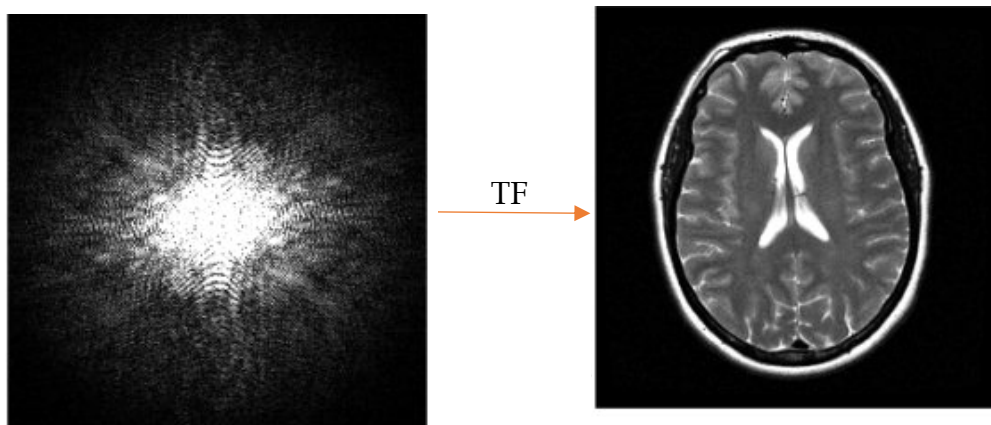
K space transformation in an image, through the Fourier Transform. Images adapted from MRI online course (Magnetic Resonance Imaging). (n.d.). Retrieved January 10, 2020, from <https://www.imaios.com/en/e-Courses/e-MRI/>
